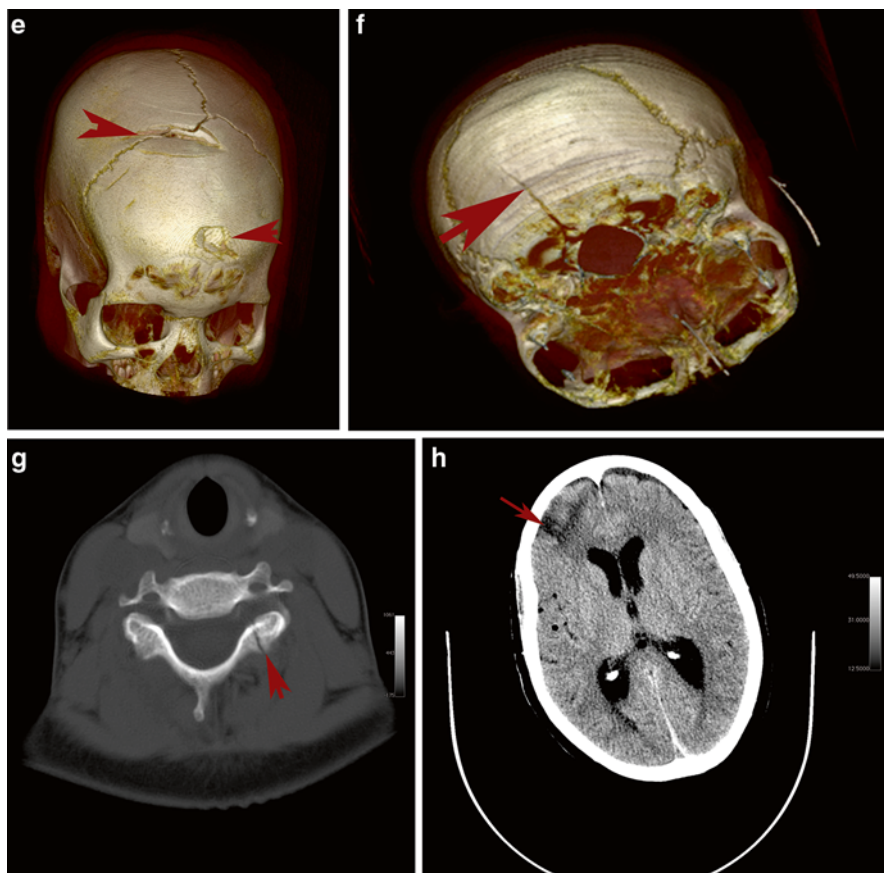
CT-brain scan of RTA: Fracture of Frontal Bone in male age 24 with headaches following RTA.
